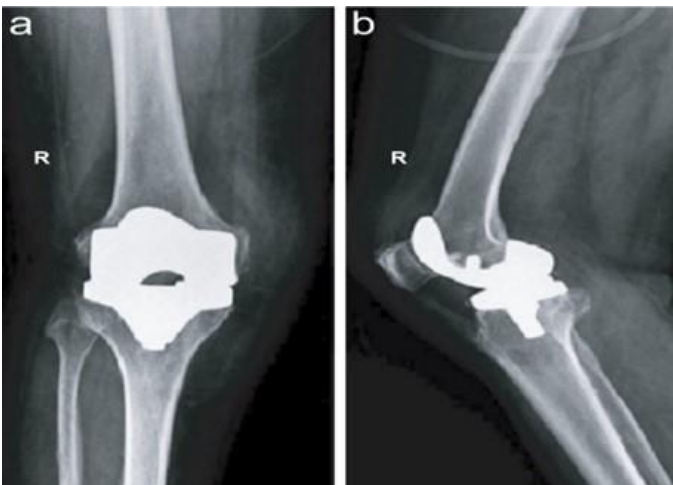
Anteroposterior (a) and lateral (b) radiographs of the right knee revealing no signs of loosening, displacement, bone loss, or osteolysis
